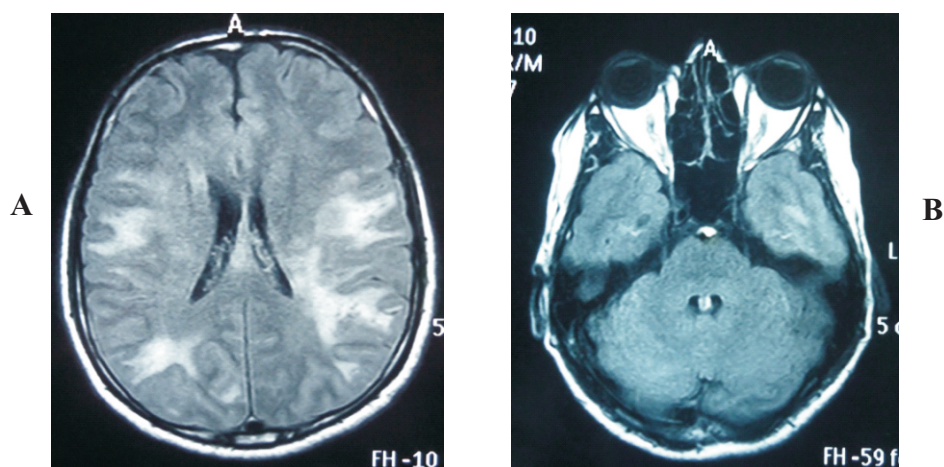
MRI Brain with FLAIR showing high signal intensity lesions in the periventricular and Subcortical deep white matter (A) High signal intensity lesions in the temporal poles
